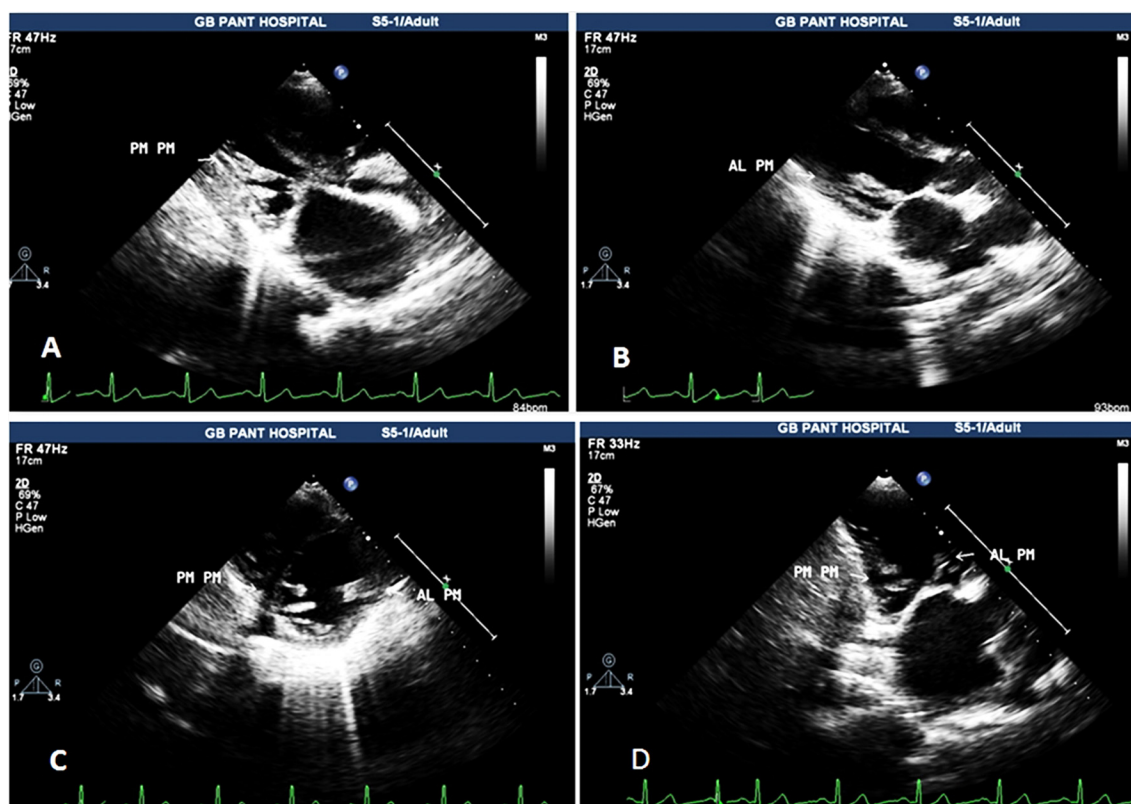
Assessment of subvalvular apparatus in mitral stenosis. While both the papillary muscles and chordae have disease, it is more extensive on the AL papillary muscle side. (A and B) Modified tilted parasternal long axis views; (C) parasternal short axis view at the papillary muscle level; (D) modified apical 2 chamber view showing both papillary muscles. AL: Anterolateral; PM: Posteromedial; PM: papillary muscle.
